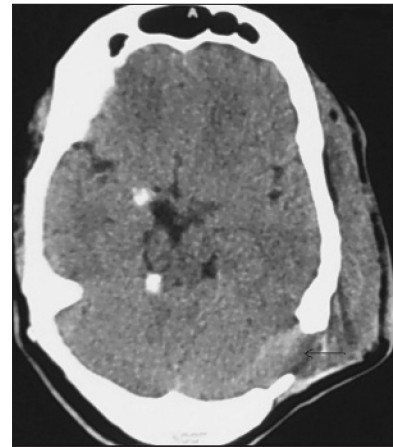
Non contrast CT head showing defect in the occipital bone (thin arrow) with soft tissue swelling. There is evidence of calcification in right cerebellum and medial perisylvian area
